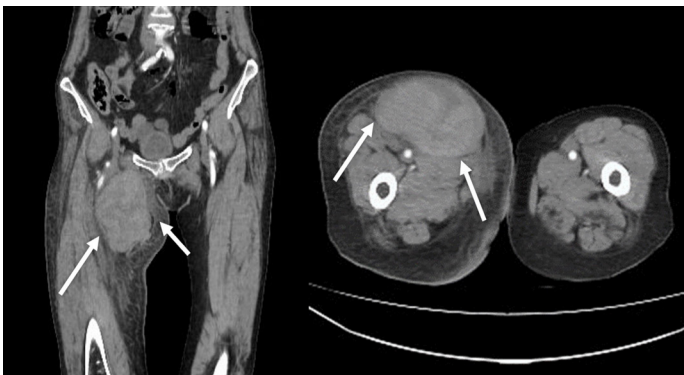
Frontal and sagittal CT angiogram view of right femoral artery pseudoaneurysm
